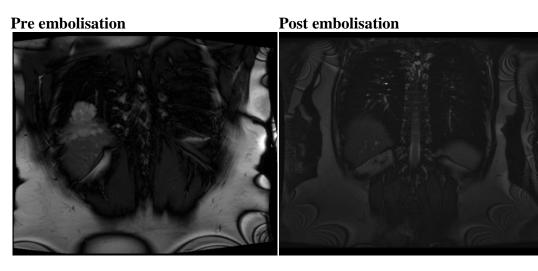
MRI Thorax (coronal sequences) demonstrating dramatic pre and post-embolisation appearances.
